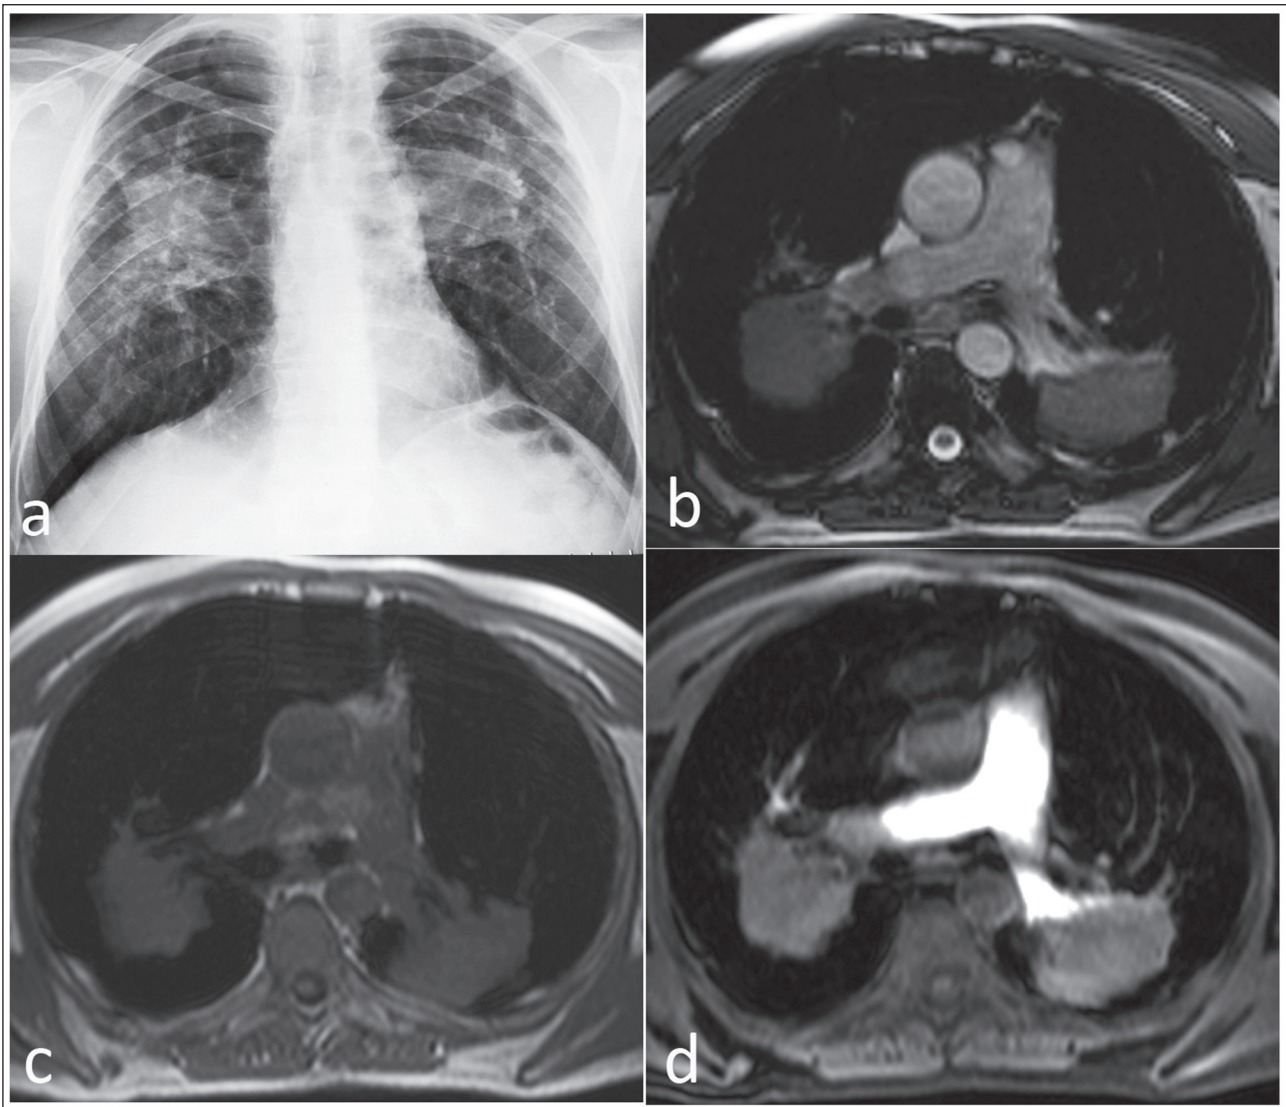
a.) PA Chest X-ray shows parahilar PMF lesions in both lungs. b.) Axial T2 weighted image, c. Axial T1 weighted precontrast image and d. Axial T1 weighted postcontrast image show slightly contrast enhanced solid lesions in both lung parenchyma.
